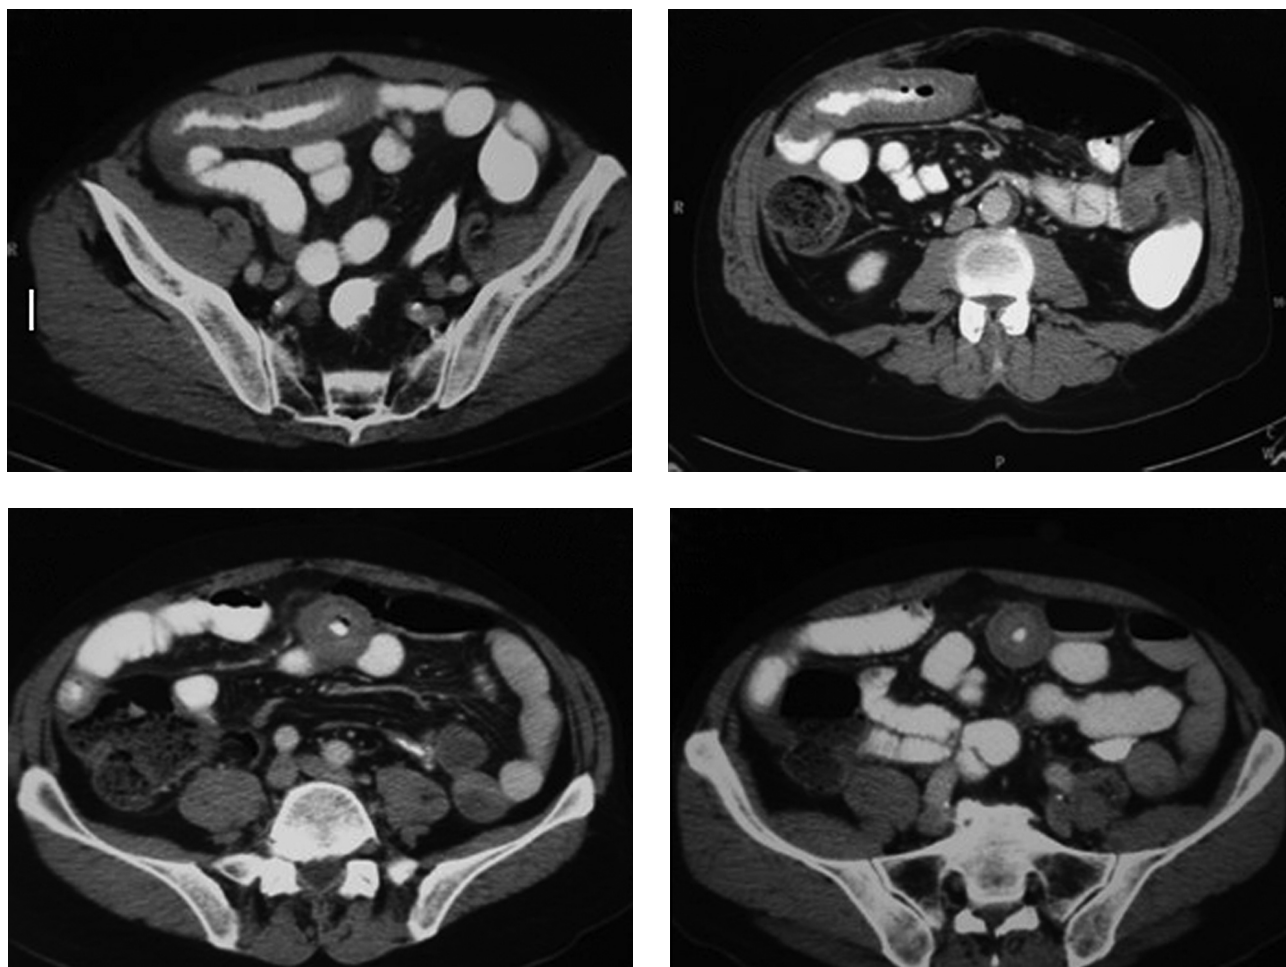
Abdominal CT showing circumferential small bowel wall thickening with intramural hyperdensity and luminal narrowing in the right lower abdomen on first admission.
